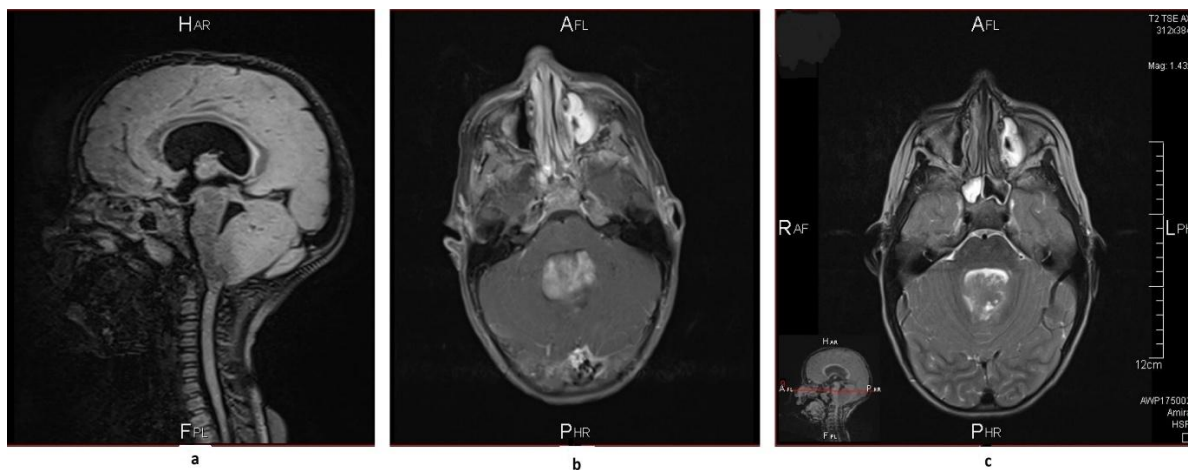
Preoperative brain MRI showing tumor in 4th ventricle in FLAIR (a), T1 with gadolinium injection (b) and T2 (c) sequences
